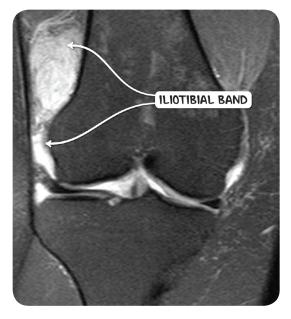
An MRI scan in the coronal plane of the right knee of individual complaining of iliotibial band syndrome symptoms. The band is inflammed with surrouding edema close to its point of insertion.
